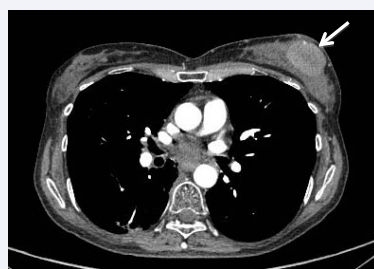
Follow-up CT scan 2 months later showing an increase in size of the left breast lesion to 4.5cm.
